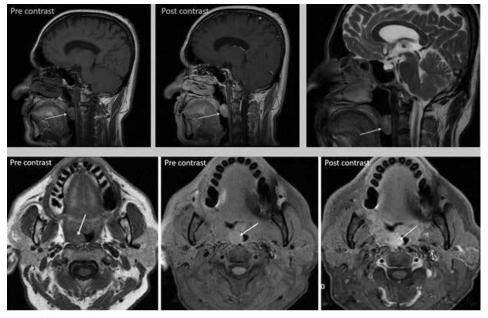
T2W and T1W MR images (Pre and post contrast) showing an enhancing lesion (white arrows) in right side of oropharynx, which has inhomogeneous iso and hyposignal on T1W images and inhomogeneous iso and hypersignal on T2W images.
